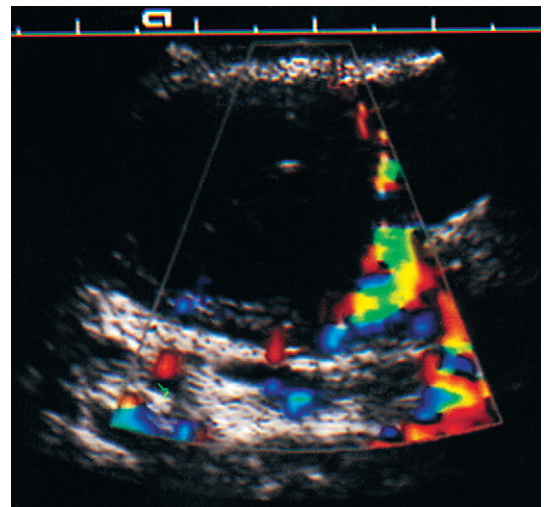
Colour flow Doppler at the margin of an apparently simple cyst but which subsequently proved to have borderline malignancy detectable in the wall.
